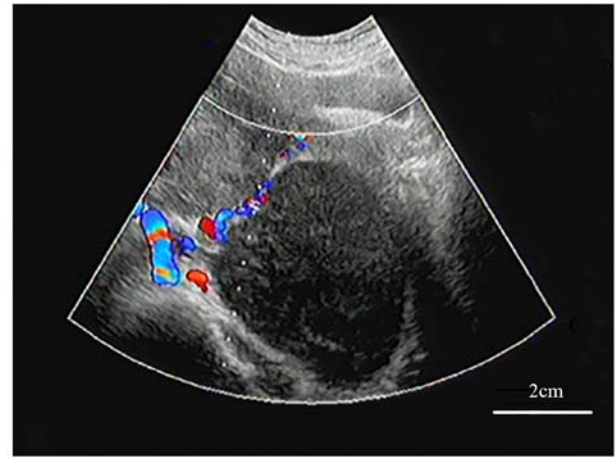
At the initial diagnosis (January 2020), B-ultrasound showed that there was a weak echo mass in the pelvic cavity and lower abdomen, the internal echo was uneven, and there was blood flow signal around the mass (scale bar, 2 cm).
